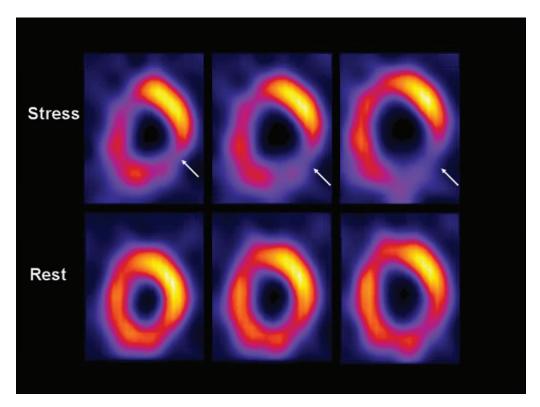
Dipyridamole thallium-201 myocardial perfusion scintigraphy. Lower images are taken at rest, and upper images during dipyridamole stress. The arrows indicate the presence of reversible perfusion defect in the lateral wall.
